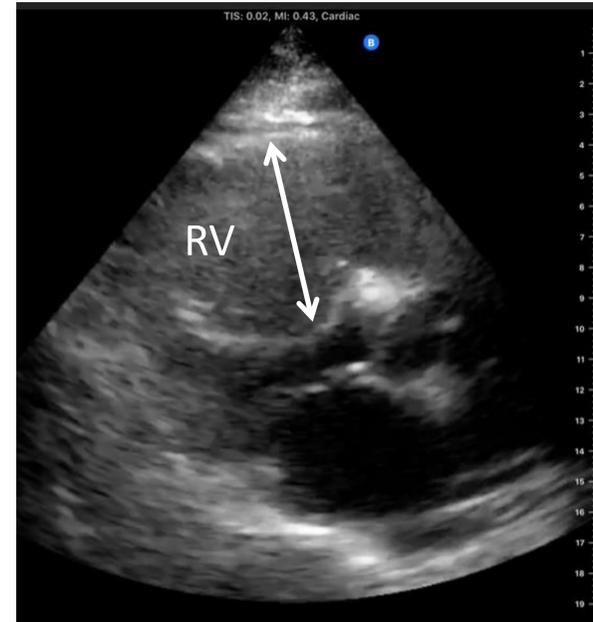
Parasternal long axis view at end systole showing severely enlarged right ventricle with bowing of the interventricular septum, concerning for RV pressure overload
